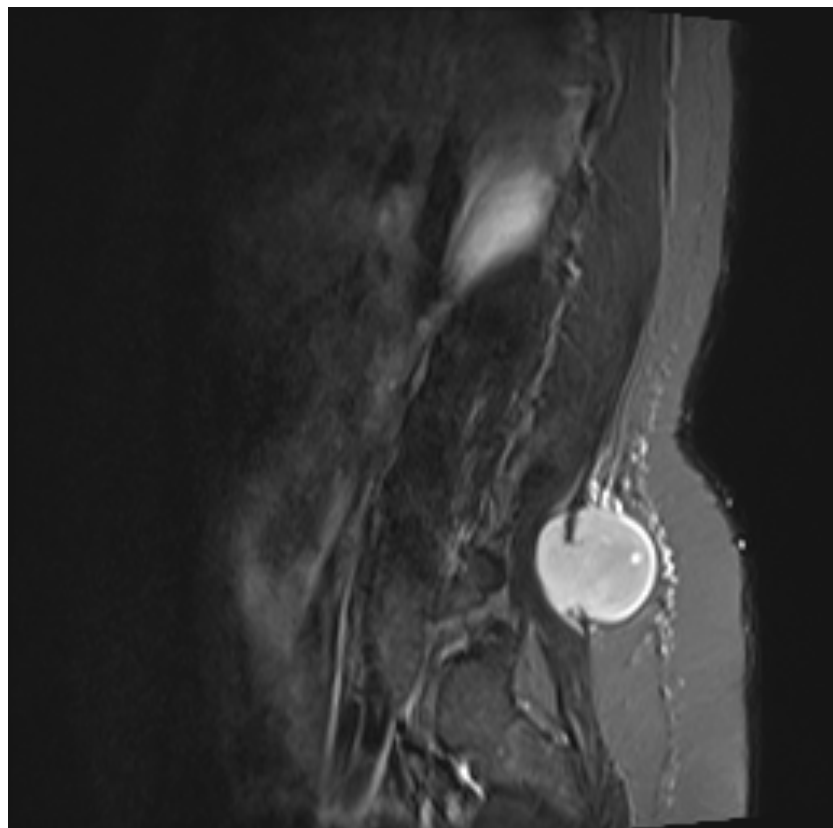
Sagittal T2-weighted image reveals the “triple signal,” characterized by the simultaneous presence of areas of low, intermediate, and high signal intensity, a pattern considered characteristic of aggressive sarcomatous tumors.
